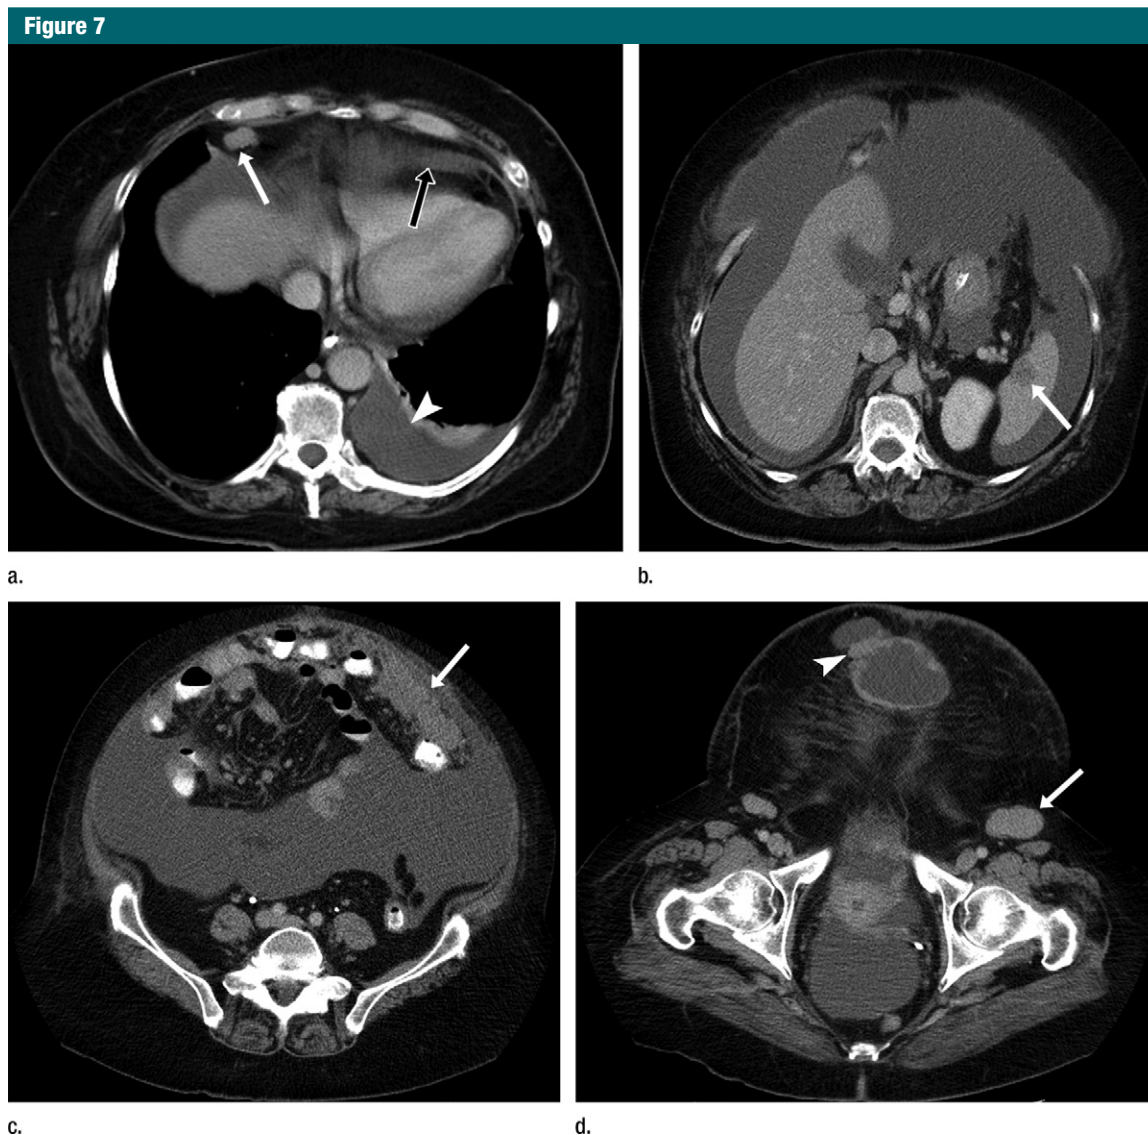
Images in a 72-year-old woman with abdominal pain and vomiting, no constitutional symptoms, and no left upper quadrant pain. Axial CT images of abdomen and pelvis with oral and intravenous contrast material raised concern for malignancy: (a) epiphrenic lymphadenopathy (white arrow), pericardial effusion (black arrow), and left pleural effusion (arrowhead); (b) splenic mass (arrow) and extensive ascites; (c) omental caking (arrow); and (d) peritoneal implants (arrowhead) and inguinal lymphadenopathy (arrow). Diagnosis of ovarian cancer was surgically confirmed.
